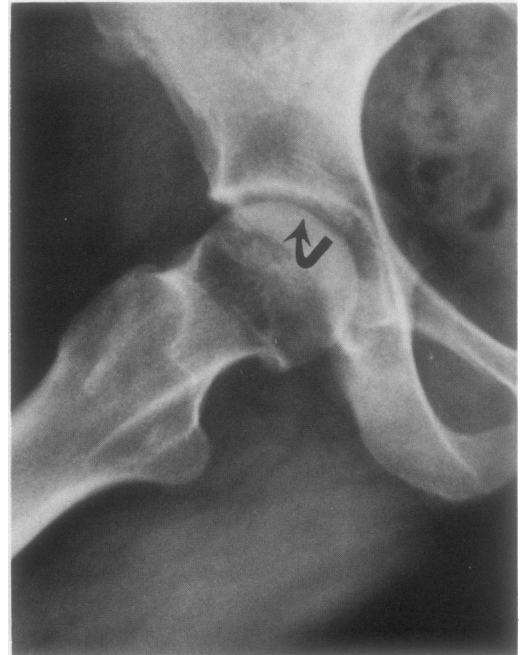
Plain radiograph of a hip in the 'frog lateral' view showing the radiolucent line ('crescent sign'—arrow) representing the subchondral fracture with deformity of the surface in stage III subchondral avascular necrosis.
